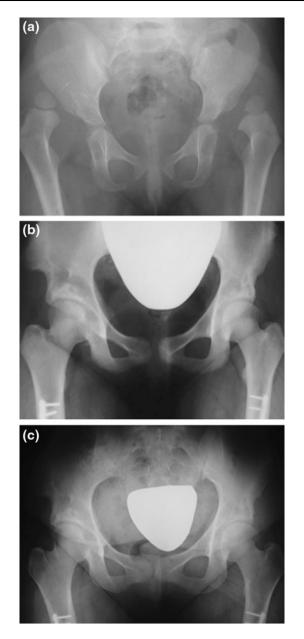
a Female patient 4 years of age with bilateral high-riding dislocations (Tonnis grade IV). Plain X-ray anteroposterior (AP) view. b Plain X-ray AP view 4 years after surgery, showing good acetabular remodeling and containment of the head of the femur bilaterally. c Plain X-ray AP view 10 years postoperatively, with excellent clinical and radiographic results
